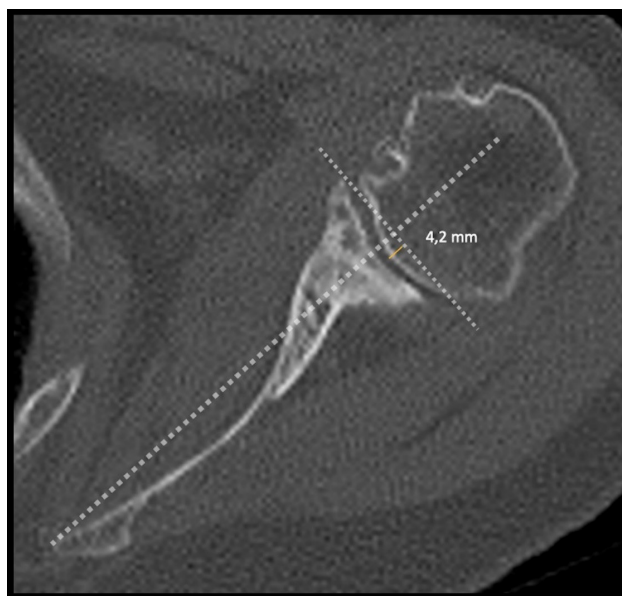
Humeral head medialization, measured by the intrusion of the humeral head medial to the premorbid glenoid line (paleoglenoid line), using axial CT images.
